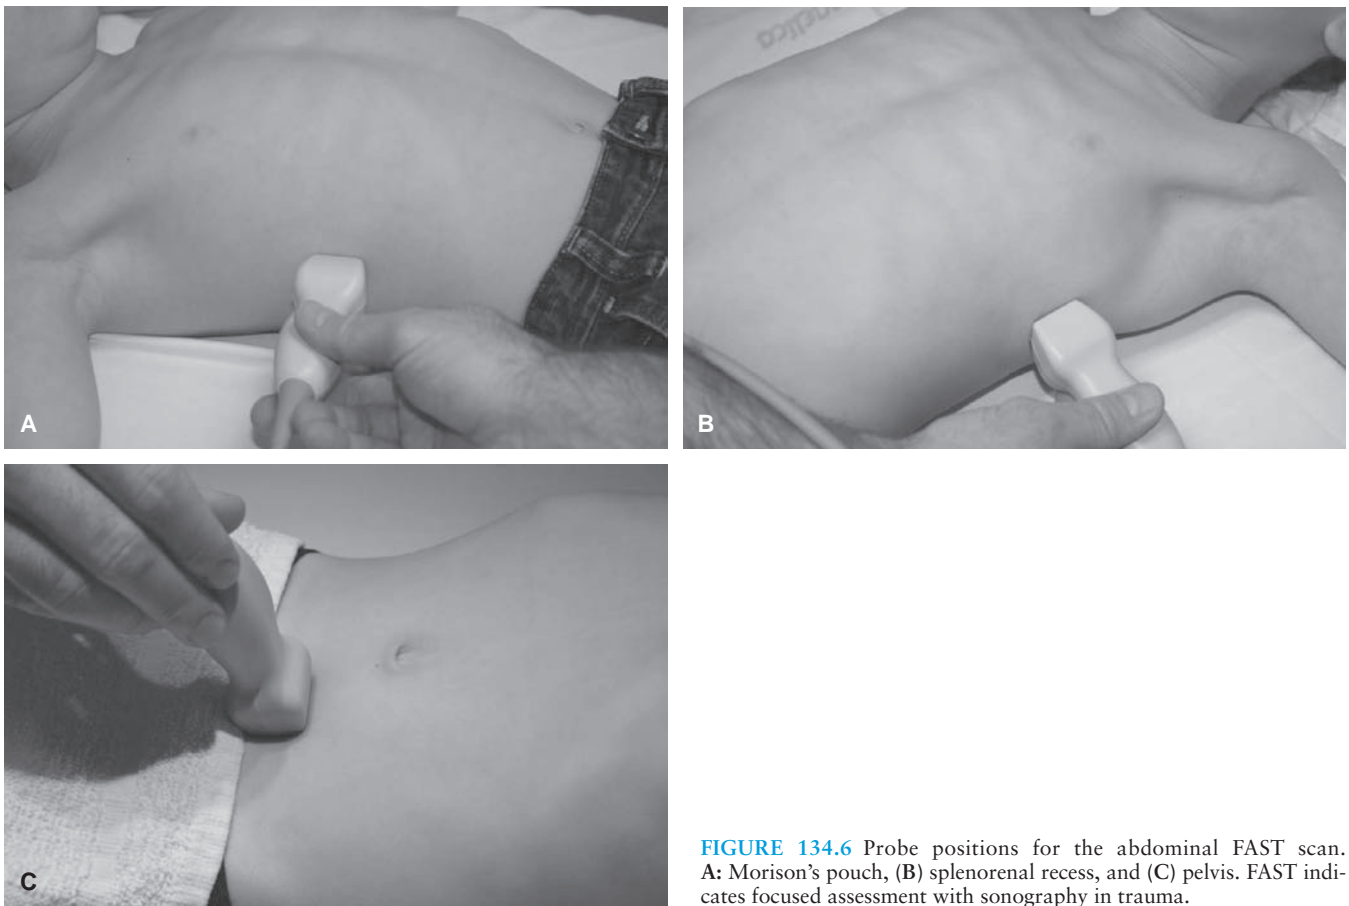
Probe positions for the abdominal FAST scan. A: Morison's pouch, (B) splenorenal recess, and (C) pelvis. FAST indicates focused assessment with sonography in trauma.
